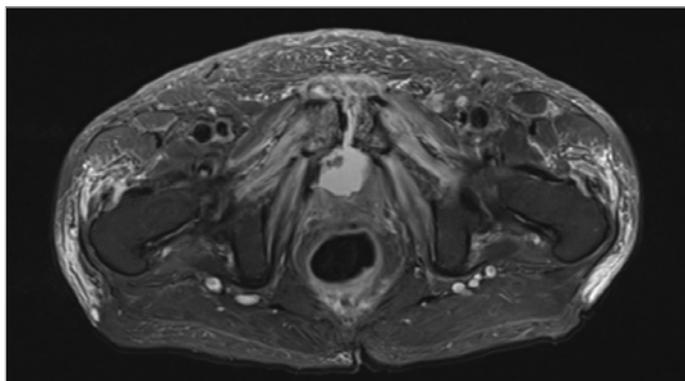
pelvic MRI showing vesico-pubic fistula and symphysitis.
